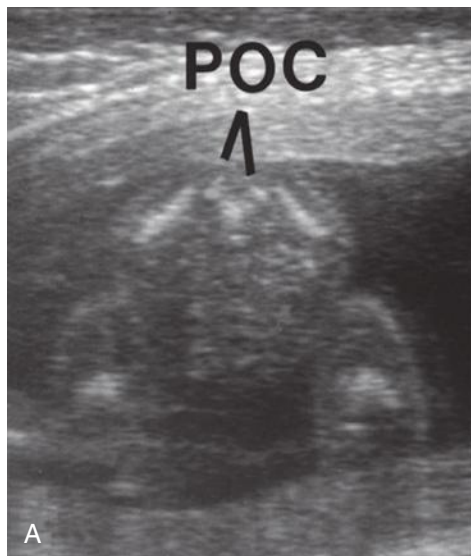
Transverse axial sonograms, sacral spine, in prone (A) and decubitus (B) positions. The posterior arch (POC) anatomy is seen well in either position. (From Filly RA, Simpson GF, Linkowski G: Fetal spine morphology and maturation during the second trimester: sonographic evaluation. *J Ultrasound Med* 6:631, 1987.)
